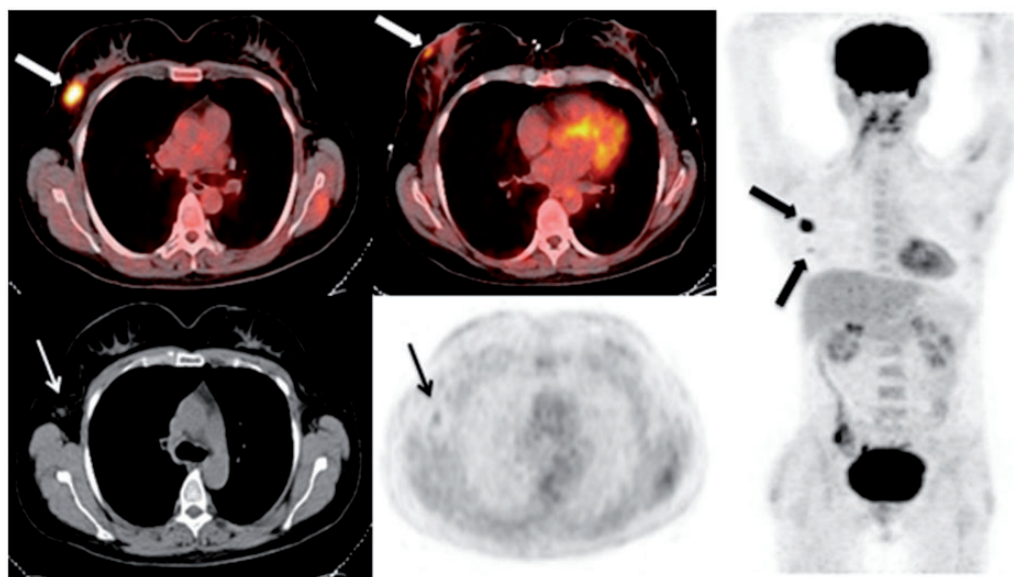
Multifocal invasive ductal carcinoma in the right breast (upper row fused images and MIP image on the right side, thick arrows). In the right axilla there was a small lymph node with moderate FDG uptake that was evaluated as positive for metastasis (bottom row CT and PET images, thin arrows). Contrast-enhanced and diffusion-weighted MRI could not detect this lymph node, however pathology confirmed the metastasis.
